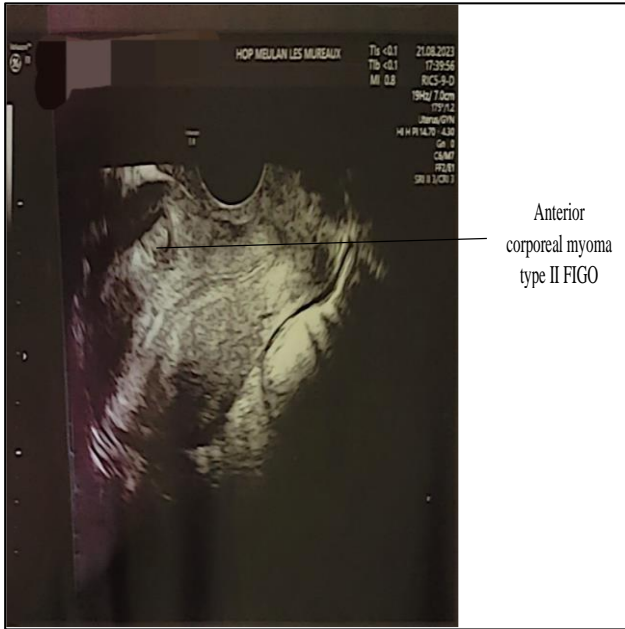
Pelvic ultrasound by engovaginal route showing an empty uterus with the presence of a 1.5 cm anterior corporeal type IV FIGO myoma.
